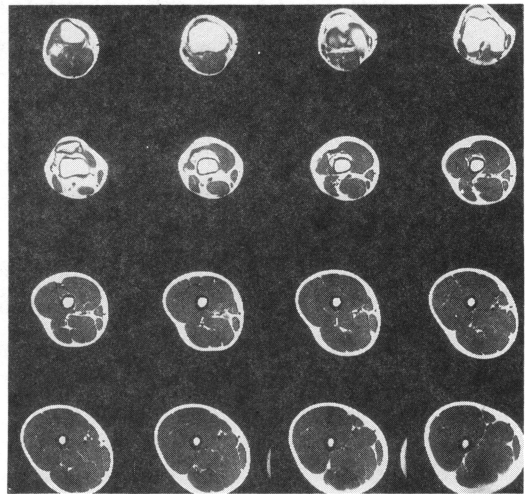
Axial image of thigh obtained from MRI.
